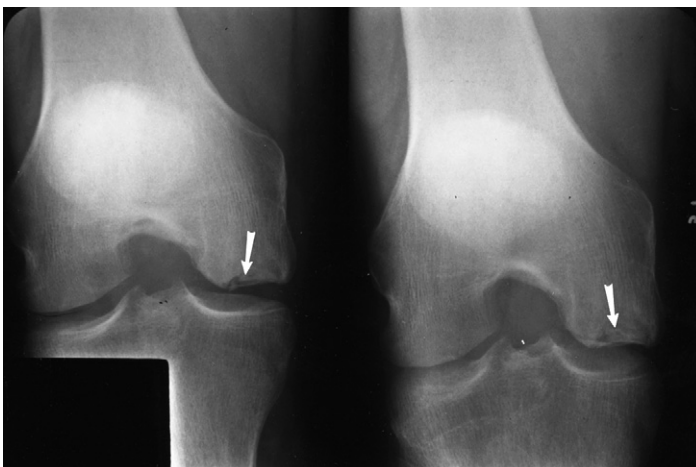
Notch views of the knee demonstrates osteochondral collapse (arrows) of the weight-bearing surface of the medial femoral condyle. (From Kelley EA, Berquist TH. The knee. In: Berquist TH, editor. MRI of the musculoskeletal system. 5th edition. Philadelphia: Lipincott-Williams and Wilkins; 2006. p. 303–429; with permission.)
